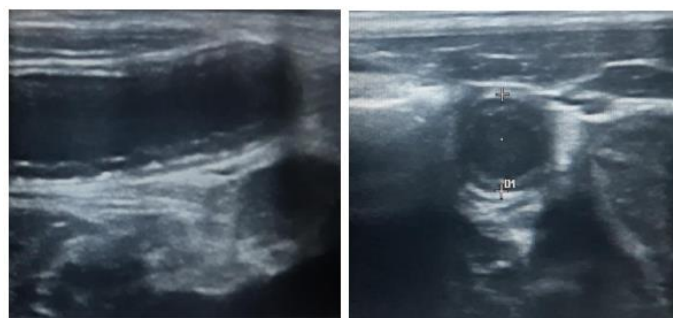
A 15years- old male patient presenting with complaints of RIF pain, High-frequency sonogram (A- longitudinal & B-transverse axis) shows a blind-ended tubular structure with thickened wall and maximal luminal diameter measuring approx. 8mm without any
